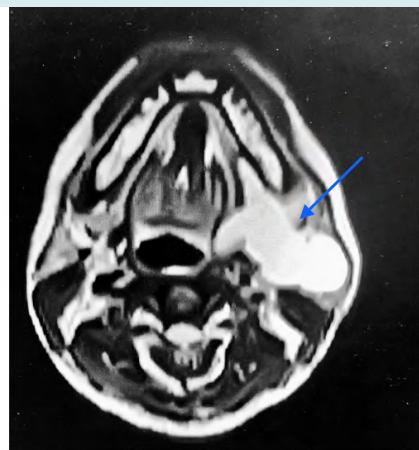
Axial MR image showing a large lipoma involving parotid, submandibular and parapharyngeal spaces.
